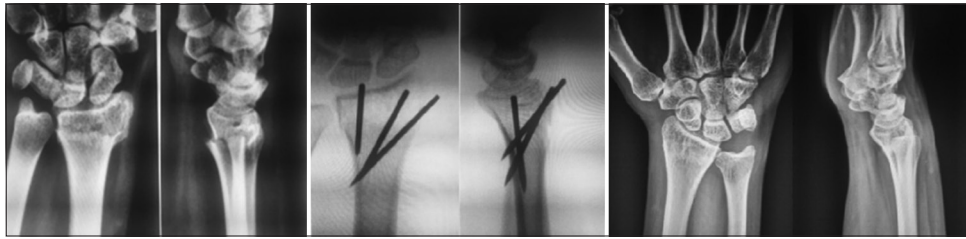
Pre-operative, post-operative and 6-month follow-up X-rays of a patient from the K-wiring insertion
